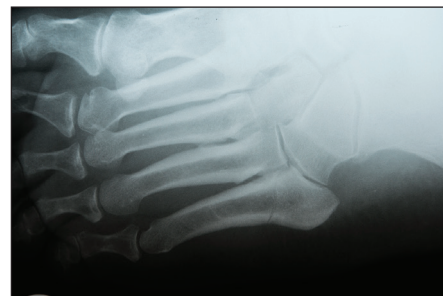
Hairline Jones fracture. Tender to touch and visible on x-ray.
